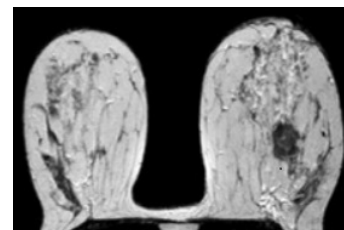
T2-weighted BMRI
